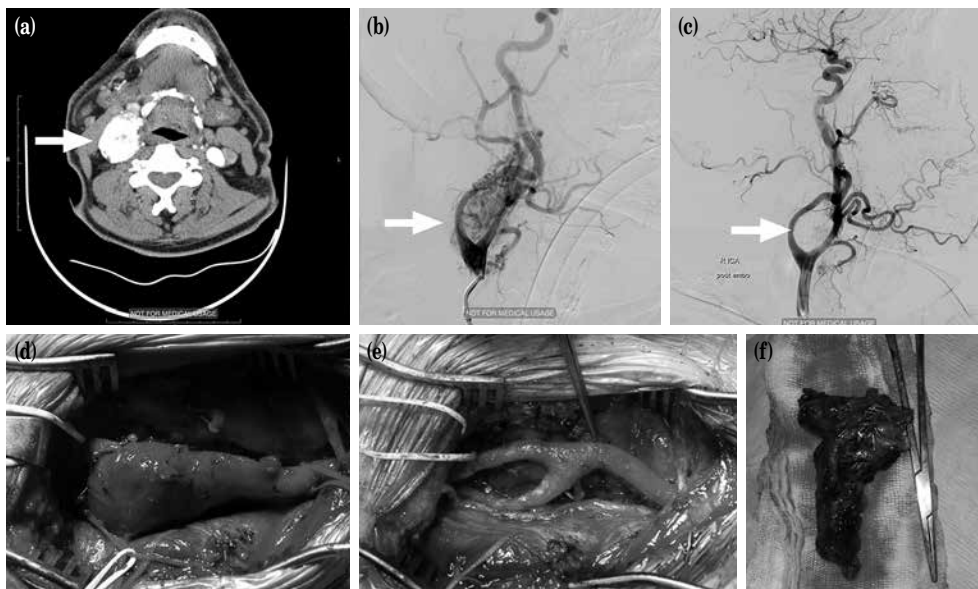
(a) A vascularized mass with a diameter of 5×6 cm on computed tomography angiography surrounding right common, internal, and external carotid arteries. (b) Preoperative angiographic view prior to surgical embolization. (c) Preoperative angiographic view following surgical embolization. (d) Intraoperative view of carotid body tumor prior to resection. (e) Intraoperative view of carotid arteries following resection. (f) Intraoperative resected carotid body tumor.
